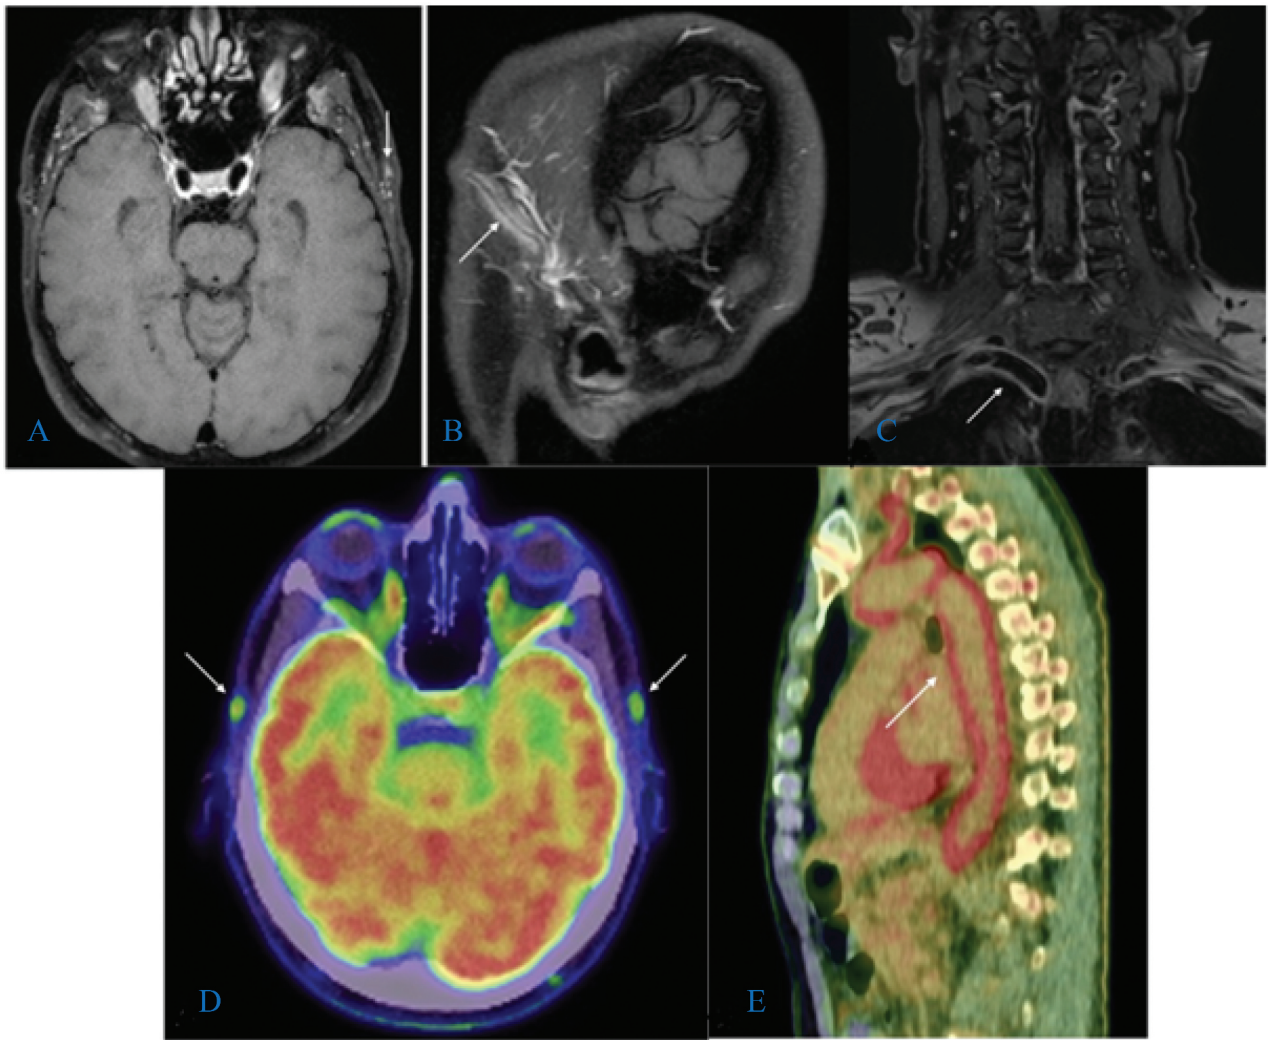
Magnetic resonance imaging (MRI) positron emission tomography–computed tomography (PET-CT) findings consistent with giant cell arteritis at the time of diagnosis. (A–C) T1-weighted three-dimensional black-blood magnetic resonance images with gadolinium contrast demonstrating pathological enhancement in the proximal segments of the temporal arteries in (A) axial and (B) sagittal views; and (C) in the right brachiocephalic artery and subclavian artery in the coronal view. (D, E) [ $^{18}\text{F}$ ]Fluorodeoxyglucose PET-CT scans revealing increased tracer uptake in (D) the temporal arteries bilaterally and (E) the ascending aorta, aortic arch, descending aorta, and abdominal aorta.
